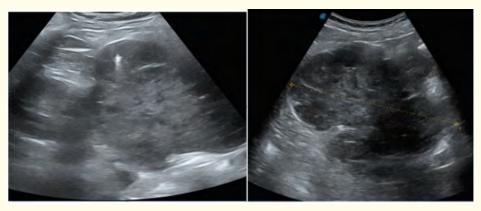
Ultrasound image showing a heterogeneous hypoechoic solid hepatic lesion with lobulated contours.
